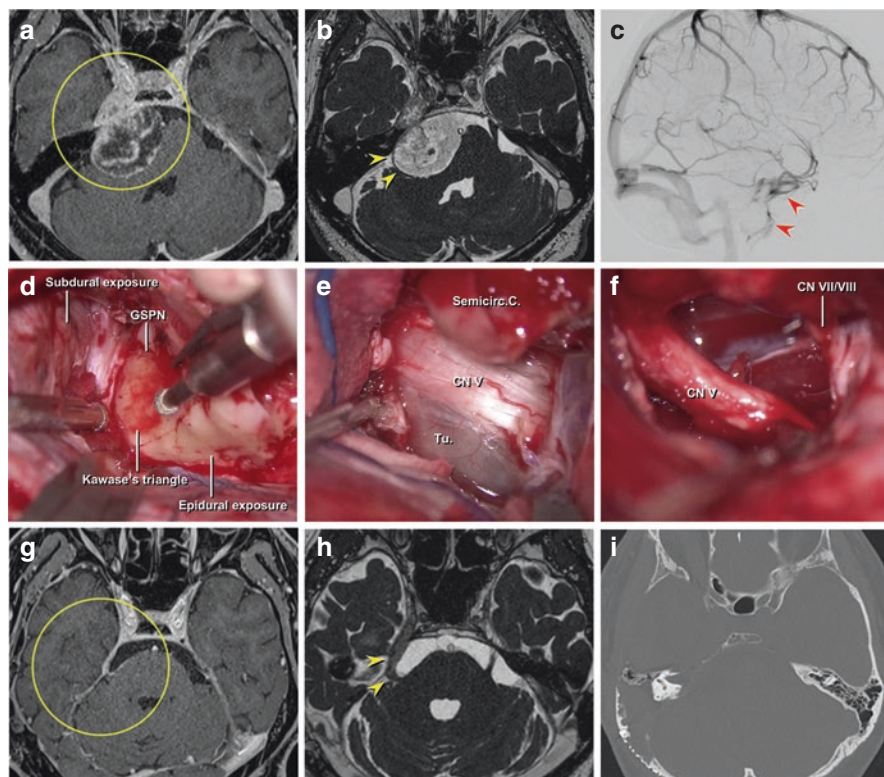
A 52-year-old man with trigeminal schwannoma (type MP) treated via the modified combined transpetrosal approach experienced improvement of preoperative facial hypesthesia. (a) Preoperative contrast T1-weighted MRI displaying a right trigeminal schwannoma extending into the posterior fossa and Meckel's cave (yellow circle). (b) The intact trigeminal fibers (yellow arrowheads) were displaced lateral to the tumor in contrast-enhanced heavily T2-weighted (CISS) imaging. (c) The sphenobasal vein (red arrowheads) to the pterygoid plexus through the foramen ovale was identified as the main drainage route of the superficial middle cerebral vein on right internal carotid angiography (lateral projection). (d) To preserve the sphenobasal vein, the ventral temporal lobe was retracted subdurally, and the dorsal middle fossa was exposed epidurally to expose Kawase's triangle. (e) The intact trigeminal fibers were displaced laterally, as expected on preoperative CISS imaging. (f) Near-total tumor resection was achieved while preserving most intact trigeminal fibers. (g) Contrast T1-weighted MRI at the 4-year follow-up displayed no residual tumor or regrowth of the tumor (yellow circle). (h) Contrast CISS image at the follow-up confirmed preserved trigeminal fibers (yellow arrowheads). The patient's preoperative facial hypesthesia was improved postoperatively (from V1/V2/V3: 9/5/5 preoperatively to 9/10/10 postoperatively) without any other neurological deficit. (i) Postoperative CT scan displaying the extent of osseous drilling around the semicircular canals. *CN* cranial nerve, *GSPN* greater superficial petrosal nerve, *Semicirc. C.* semicircular canals, *Tu.* tumor
